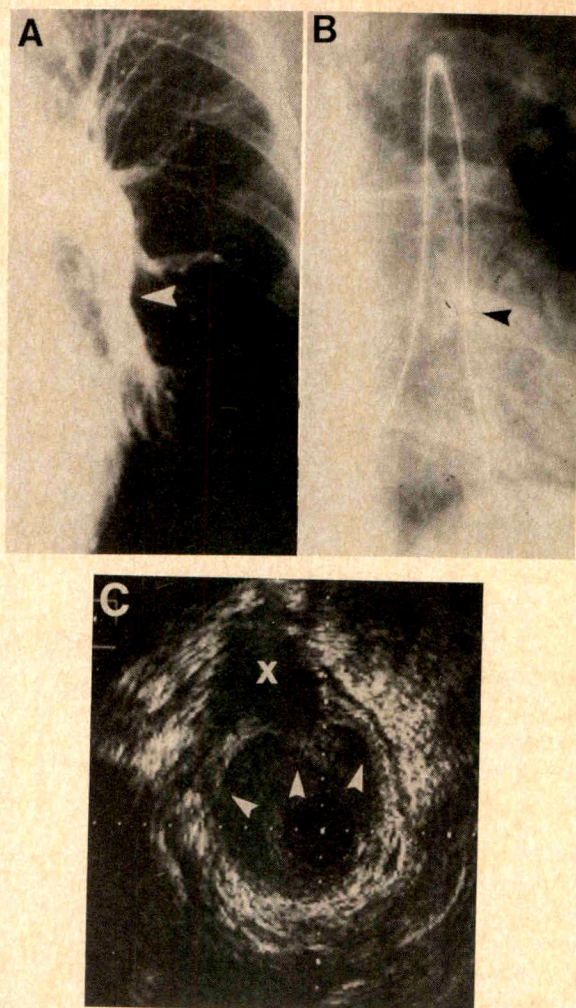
A*, angiographic image of the left pulmonary artery showing a mild tapering of the inferior branch (arrow). *B*, the intravascular ultrasound imaging catheter is positioned in the left inferior lobe pulmonary branch (arrow). *C*, intravascular ultrasound image of the left inferior lobe pulmonary branch showing a "crescentic layer" appearance of the vessel wall (small arrows) (1 mm between dots). X = presence of a side branch.
